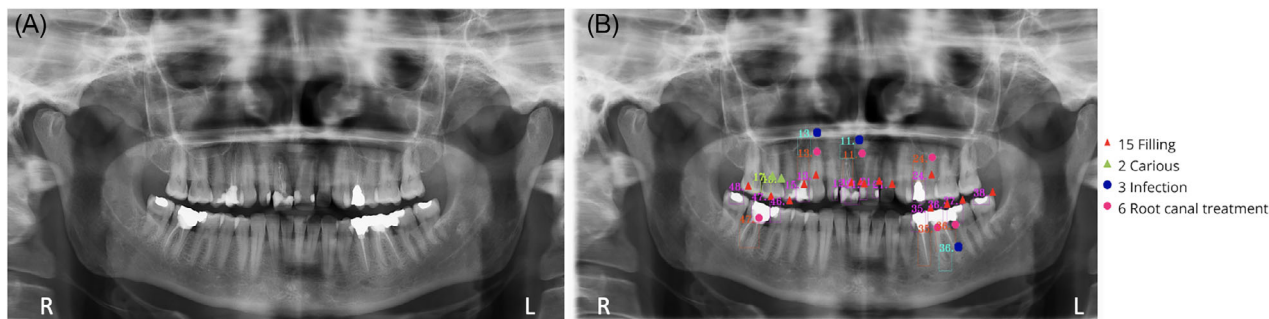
Panoramic radiograph (A) and artificial intelligence (AI) output image (B) with detection squares and symbols for detected diseases (fillings, caries, apical lesions, etc.), as well as the Fédération Dentaire Internationale (FDI) notation of the affected tooth.
